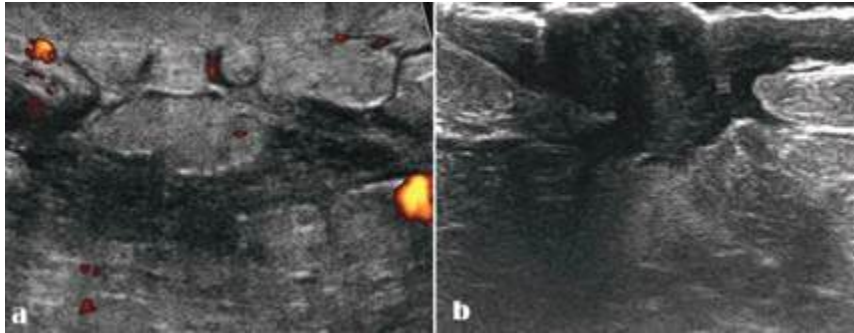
Ultrasound findings of right breast abscess.
